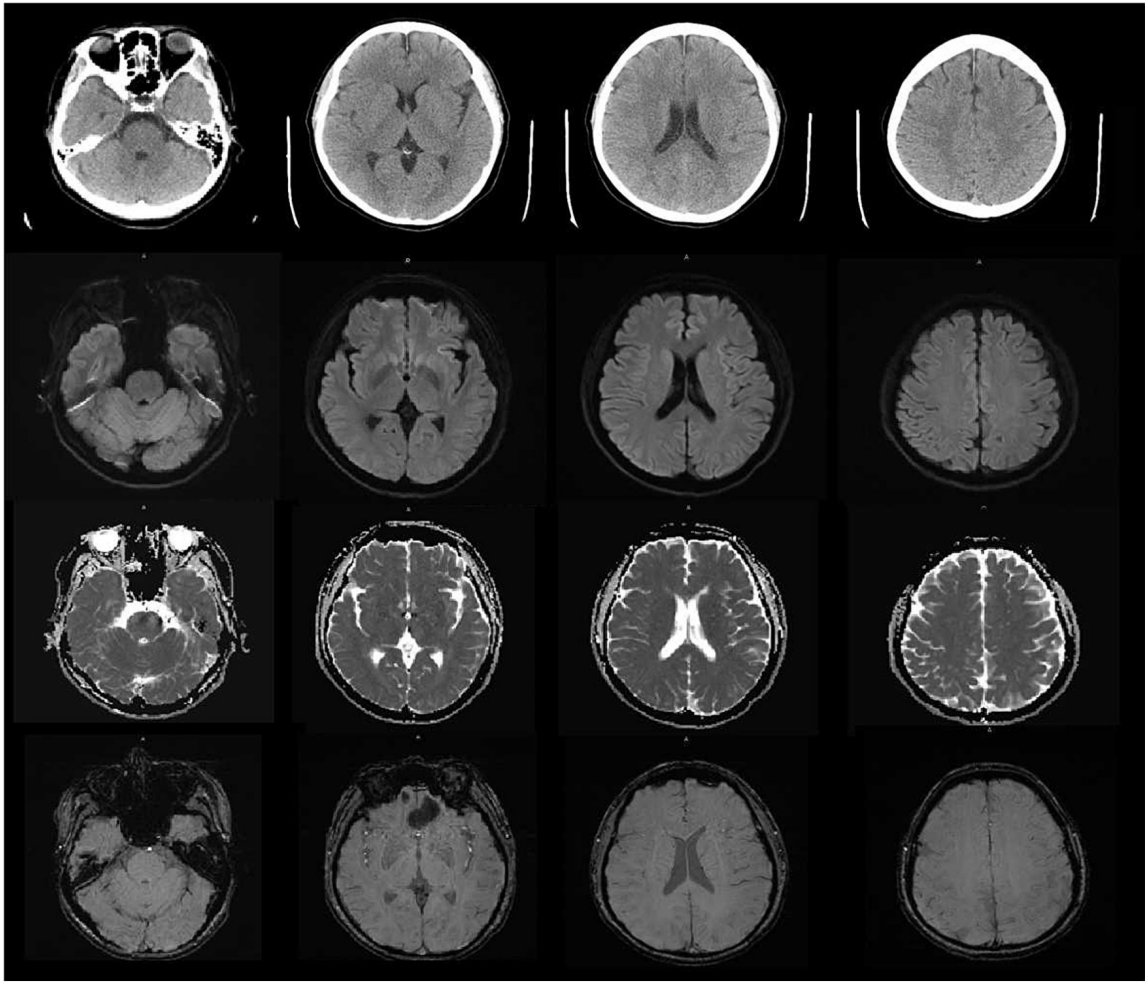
The cranial MRI showed no abnormal signal was found in T1-weighted imaging,T1WI (T1), T2-weighted imaging,T2WI (T2), diffusion-weighted imaging (DWI) and susceptibility weighted imaging (SWI).
